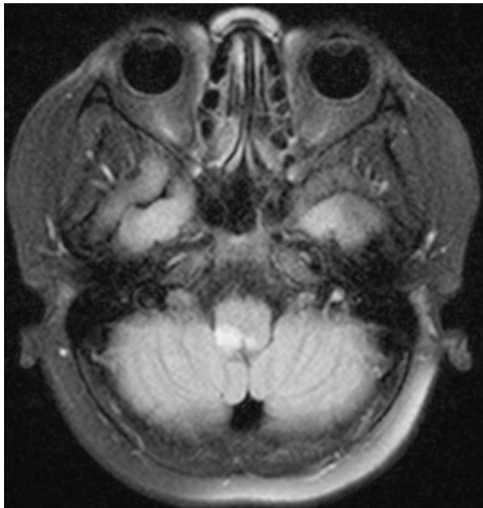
MRI T2-FLAIR sequence demonstrating hyperintense signal involving AP extending to the right side of the medulla and corticomedullary junction has significantly increased. FLAIR: fluid-attenuated inversion recovery.
